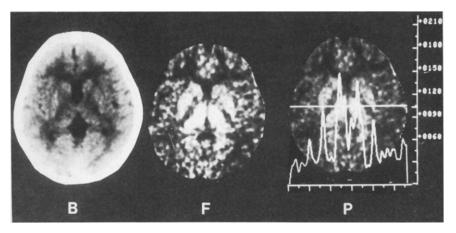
The preoperative CT image (\underline{B}) and blood flow map (\underline{F}) in case 10 demonstrates the typical flow pattern in Moyamoya disease. In the cortices rCBF is low, while in the thalamus and putamen it is normal. This pattern is also evident in the rCBF profile (\underline{P}) .
